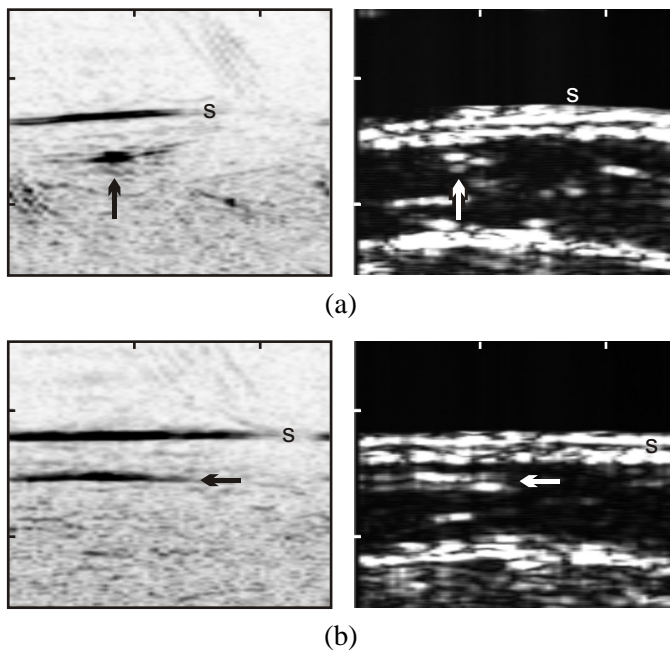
In-vivo* optoacoustic images (left) and corresponding ultrasound images (right) of a vein at the interior part of the medial lower leg. The images cover a 2.6×2.0 cm area. (a) Cross section image from the interior part of the leg. In the optoacoustic image (left) the skin is visible as a black line (s). 4 mm below the skin a blood vessel (V. saphena magna) reveals itself as a pronounced black spot (arrow). The boundaries of the blood vessel are also visible in white on the ultrasound image (right) at the same location. Just right of the large vessel a smaller one is visible in the optoacoustic image. On the right half of the image approximately 8 mm below the skin another small blood vessel is visible in both images. (b) coronal configuration images acquired at the same position but with 90° turned transducer. The black upper line in the optoacoustic image (left) originates from the skin (s). The black line 4 mm below the skin (arrow) corresponds to the longitudinal section of the vein, which is also visible as two white lines in the ultrasound image (right). The contrast of the ultrasound images was increased by gamma adjustment. This was not necessary for the optoacoustic images. The optoacoustic images were acquired with a single 15 mJ laser pulse. No averaging was applied.
